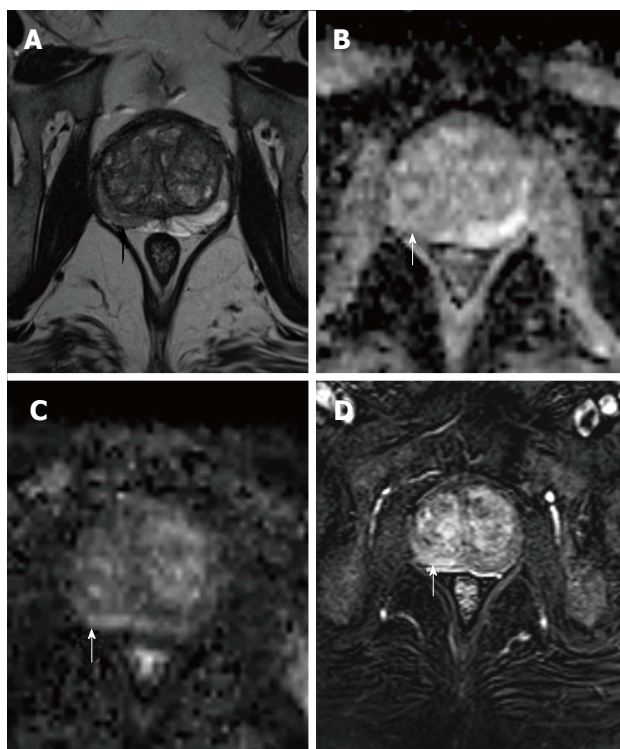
Prostate magnetic resonance imaging of a 64-year-old patient. A: T2-weighted image shows an area of hypointensity in the right peripheral zone of the midgland of the prostate (black arrow); B: A discrete restriction of diffusion in ADC map (white arrow); C: DWI image (white arrow); D: Enhancement on DCE image (white arrow), suggestive of prostatitis, confirmed by transrectal ultrasound biopsy.
